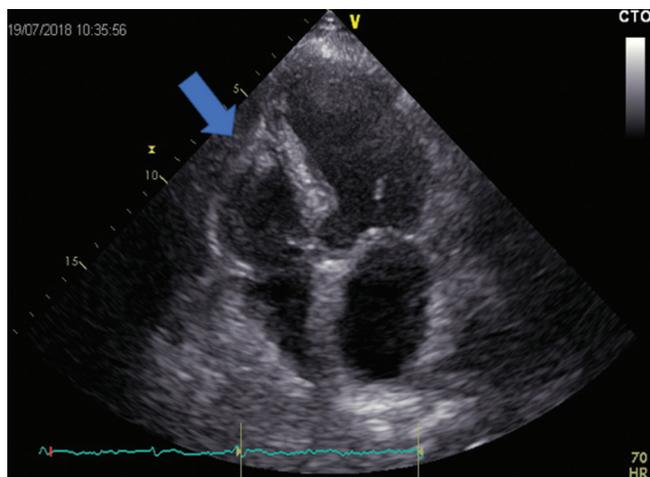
Transthoracic echocardiography can show regional right ventricle dysfunction with severe free wall hypokinesis and apical sparing (McConnell sign) as a specific finding for pulmonary embolism
